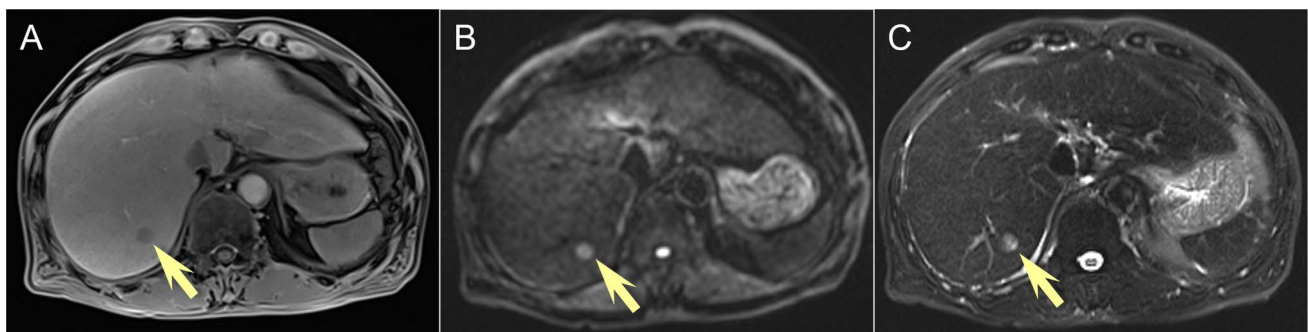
Positive finding on hepatobiliary-phase abbreviated magnetic resonance imaging (HBP-AMRI). In a 56-year-old man with hepatitis B-associated liver cirrhosis, HBP imaging (A) shows a 1.2-cm hypointense observation in liver segment VII (arrow). This lesion shows restricted diffusion on diffusion-weighted imaging (B, b -value
